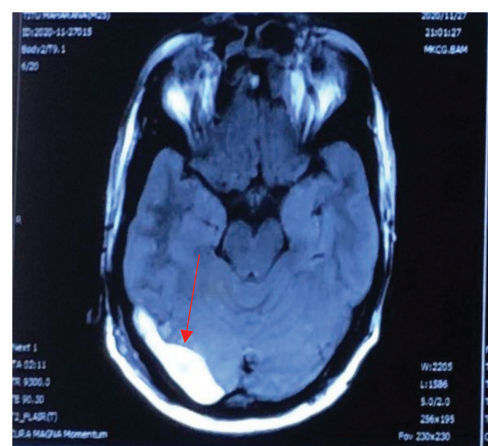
MRI brain showing FLAIR hyperintensity along right transverse sinus, suggestive of thrombosis.(red arrow)
